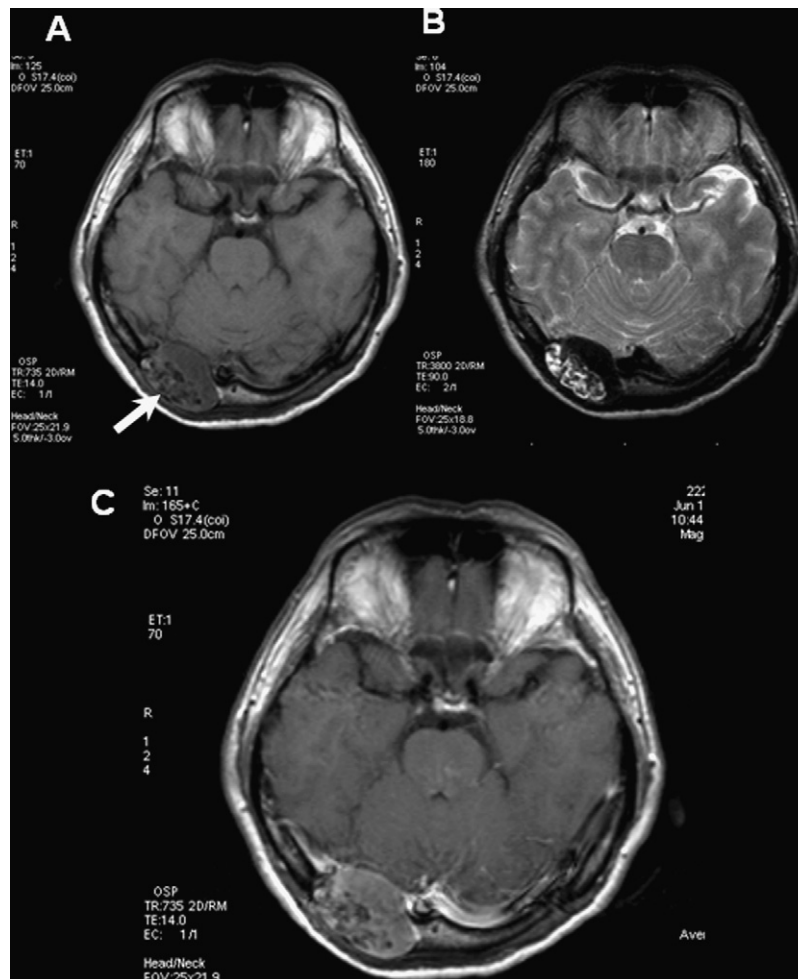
MRI brain (axial T1-weighted (A), T2-weighted (B) and T1-weighted post-gadolinium (C) images). T1-weighted image showed a well-circumscribed extra-axial mass arising from the diploic space of the right occipital bone with destruction of the inner and outer tables. A thin hypointense rim (arrow) is seen, mainly at the outer aspect of this mass, probably representing the periosteum. The clustered areas of signal void seen on T1- and T2-weighted images represent areas of calcifications or ossifications. Post-gadolinium image showed heterogeneous enhancement of this mass.
